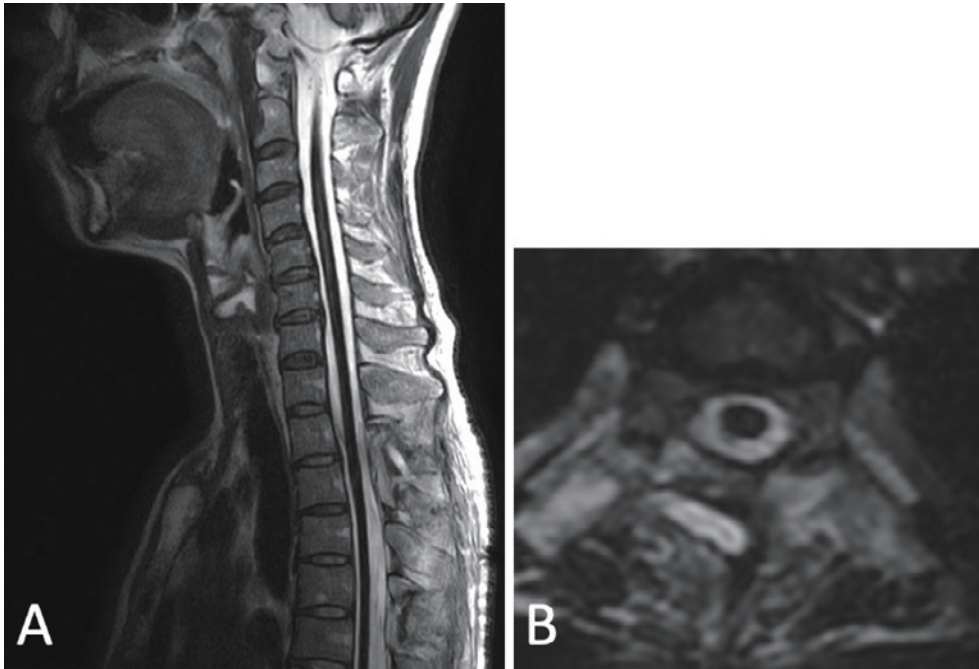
Postoperative sagittal (A) and axial (B) CISS MR images of the spine. There is no intraspinal fluid collection and no dural defect. CISS, constructive interference in steady-state; MR, magnetic resonance
